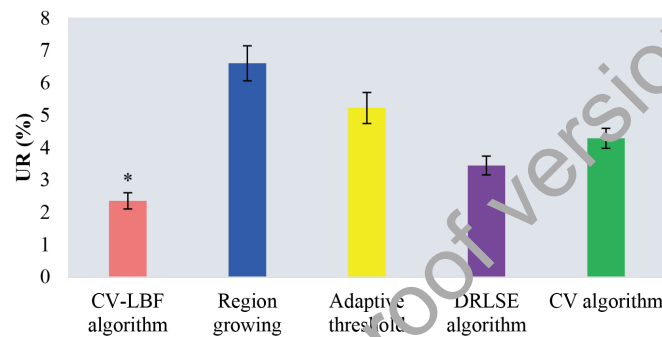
Comparison of *UR* values of segmenting CBCT images by different algorithms.
